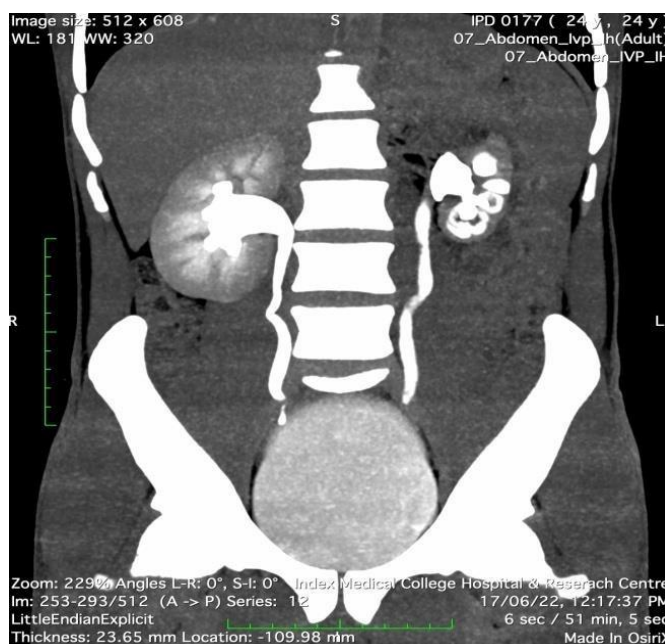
Normal CT Urogram coronal image
